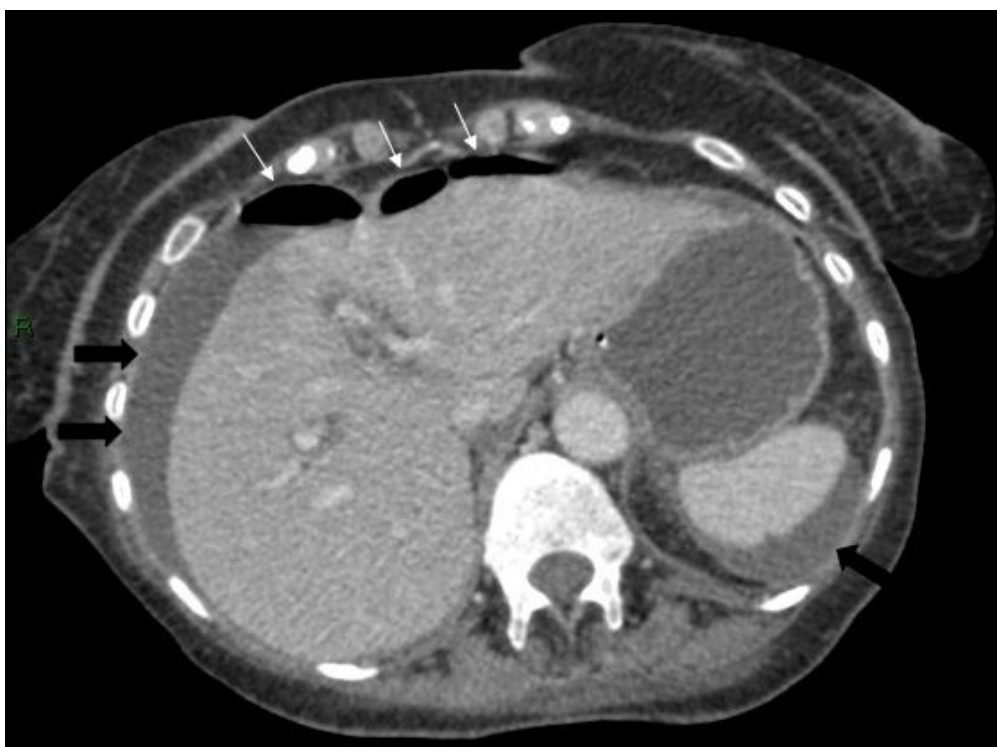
Axial CT scan of the abdomen showing free air anterior to the liver (white arrows) and free fluid around the liver and spleen (black arrows).
